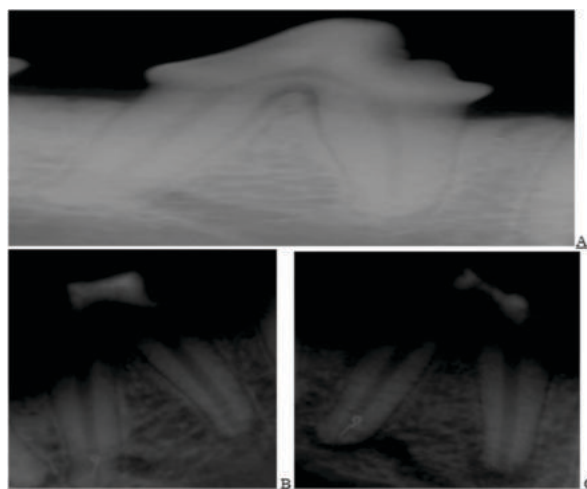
(A) an X-ray of the tooth before treatment, (B) an X-ray of the same tooth just after root canal treatment, and (C) an X-ray taken three weeks after treatment and just before sampling.
